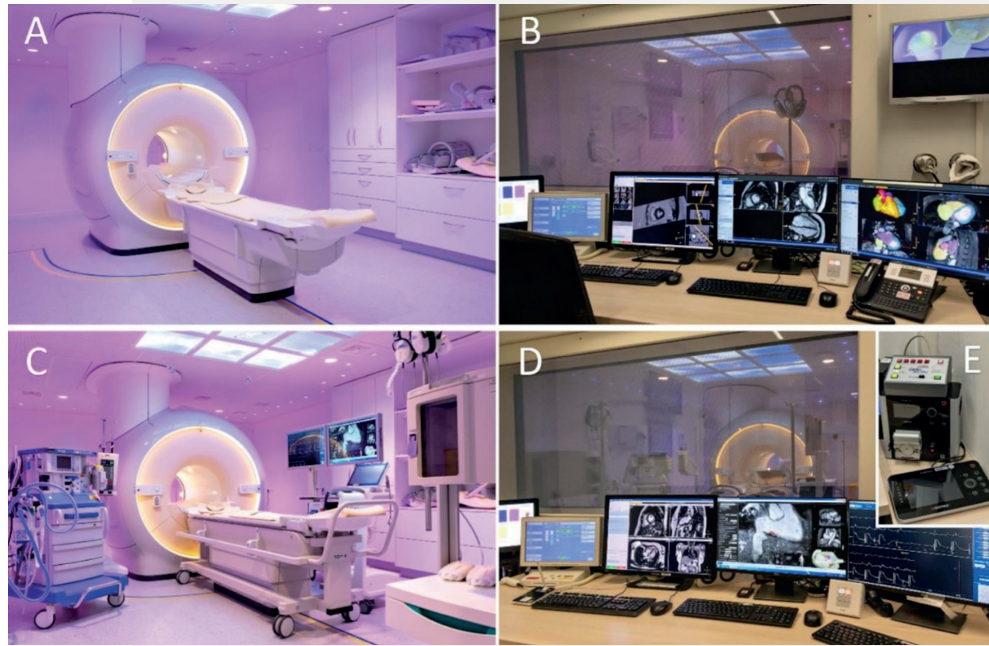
Full transformation of the pre-existing MRI environment (A,B) into an interventional cardiac MRI suite (C,D,E).
